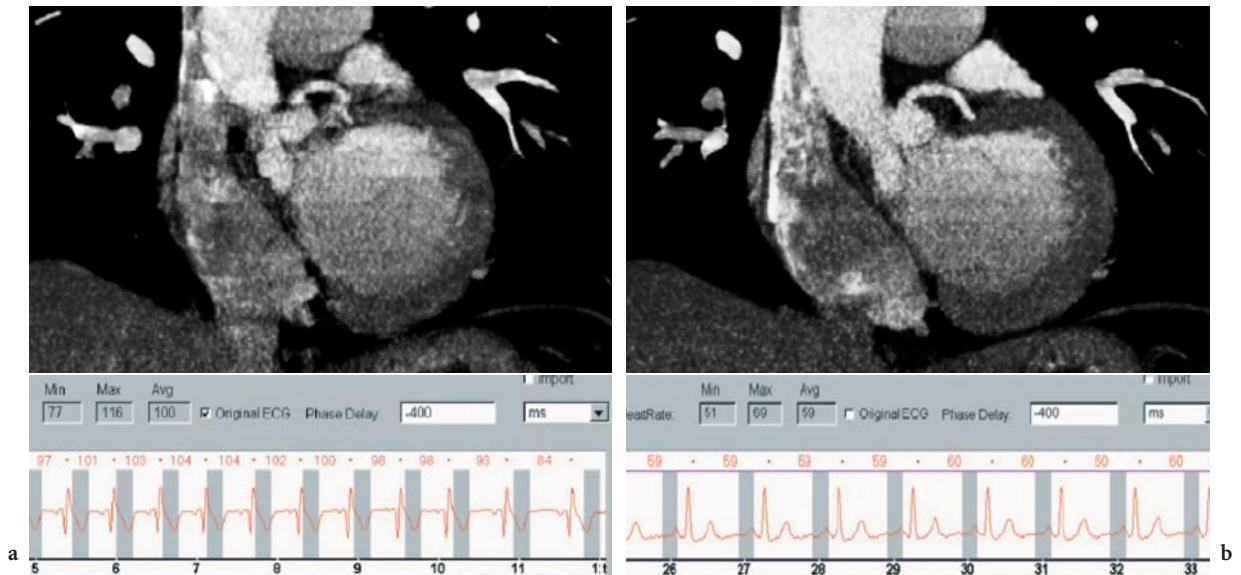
Coronary CT angiography examinations of a patient with a high and irregular heart rate. A 64-slice CT scanner with 0.6-mm collimation and 0.33-s rotation time was used. a Motion and stair-step artifacts are present in the first examination, during which the patient's heart rate varied between 84 and 104 bpm. b After the administration of β -blockers, the patient showed stable sinus rhythm between 56 and 60 bpm during the scan and diagnostic image quality could be achieved. (Case study courtesy of Klinikum Grosshadern, University of Munich, Germany)
